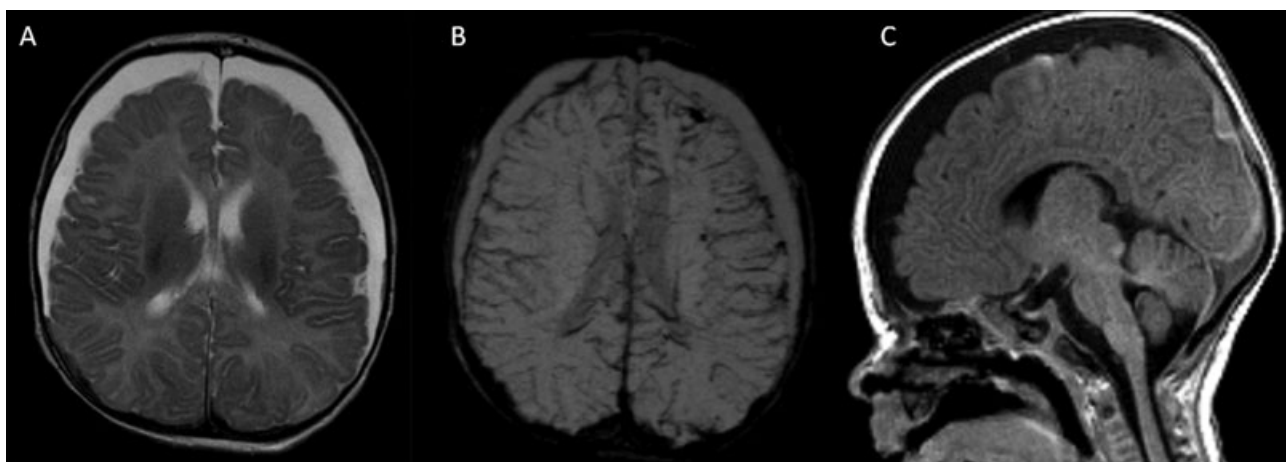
Axial T2-weighted (A), SWI (B), and sagittal T1-weighted (C) MR images of a child with chronic T2-hyperintense subdural hygromas as complication of child abuse. SWI shows small hypointense hemosiderin depositions (B) along the compressed brain surface. The hemorrhagic components are mildly T1-hyperintense.
